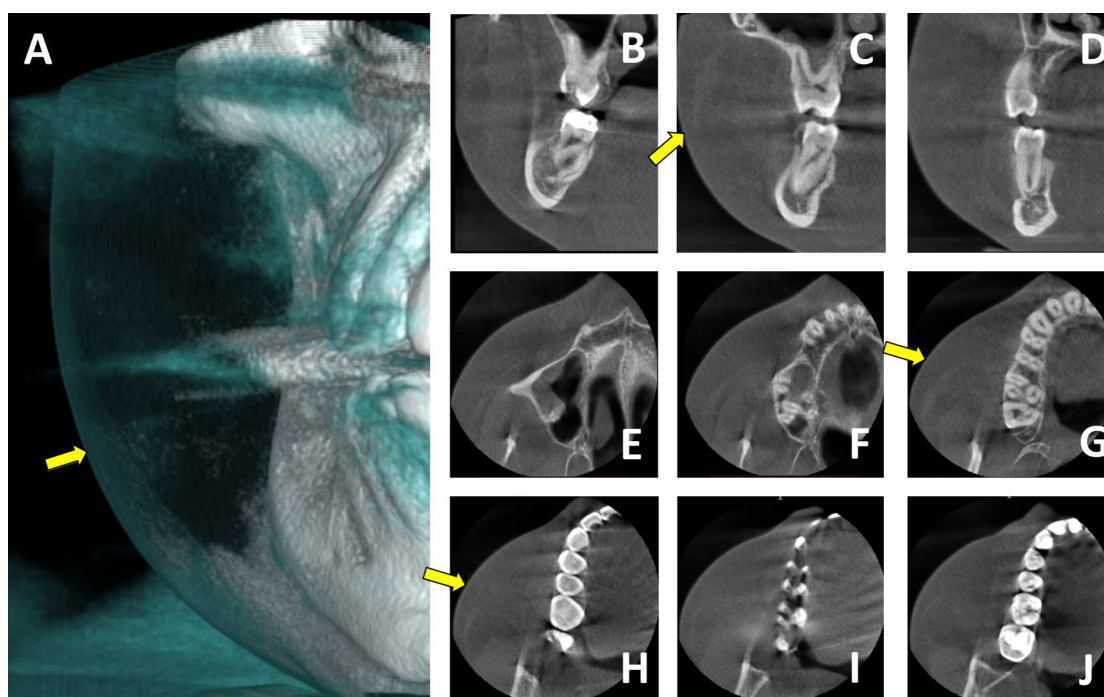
Computed tomography images of hematoma 3 d after anesthesia. Images were obtained using RadiaAnt DICOM Viewer (version 2021.2.2). (A) Three-dimensional view using the filter "bones and skin 1"; (B–D): Coronal views of the second molar (B), first molar (C), and second pre-molar (D) regions; (E–J): Axial views of the maxillary sinus (E), apical third (F), middle third (G), coronal third (H), maxillary cuspid (I), and mandibular cuspid (J). Yellow arrows denote the soft tissue limits.
